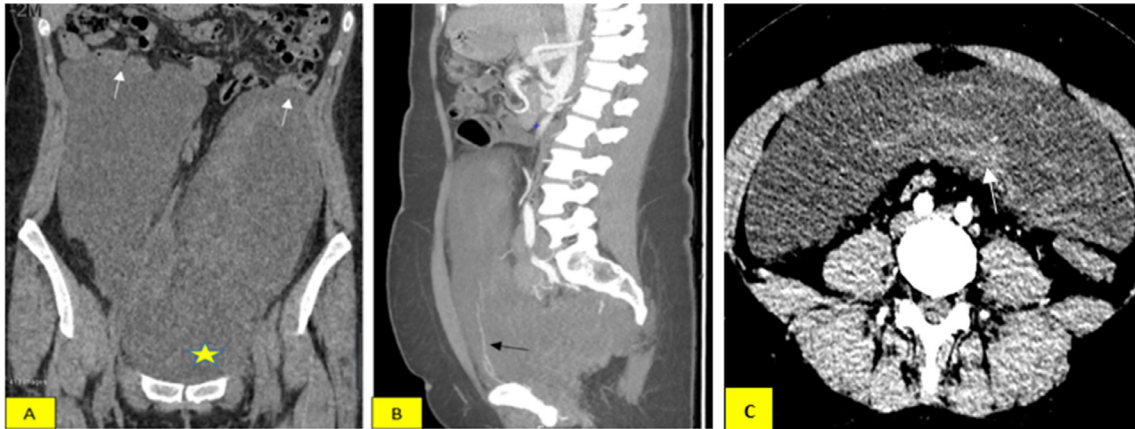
(A) Unenhanced coronal CT images indicate a huge mass displaces intra-abdominal, partly compressing nearby loop of intestinal (white arrow), relatively homogeneous hypointense mass, and no sign of bleeding or calcification inside (star shape). (B) The sagittal arterial phase with MIP reformatted after administration shows heterogeneous enhancement; there is a clear observation of vessels within the mass (black arrow). (C) Axial arterial phase, the mass shows a lesion with heterogeneous hypodensity, with inside areas of contrast enhancement (arrow).
